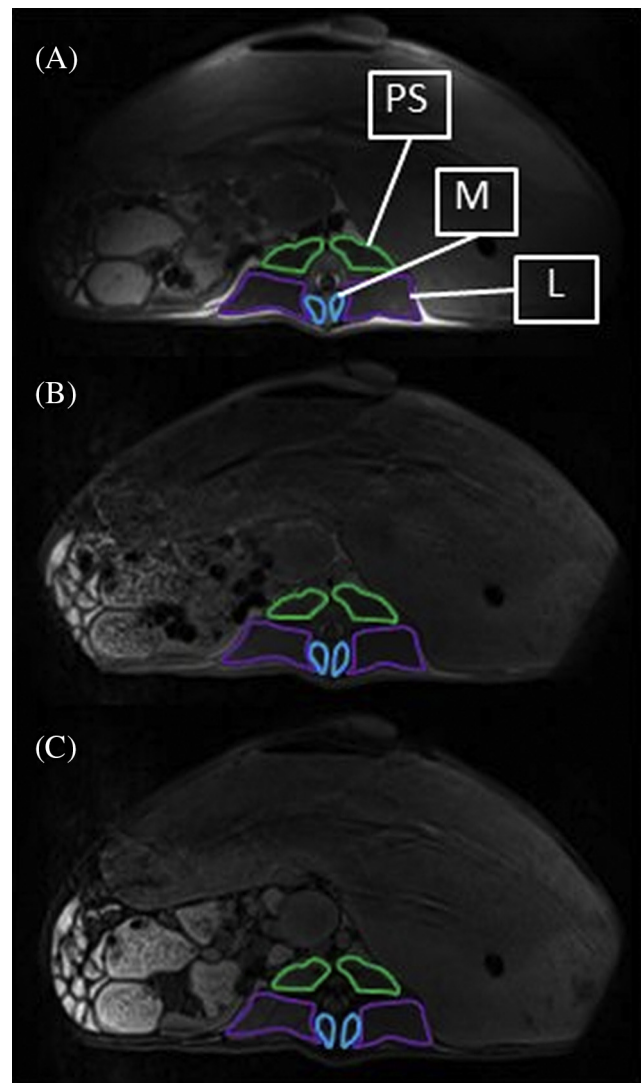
Region of interest of psoas major and minor (PS), multifidus (M), and longissimus (L) on both sides of L4 in (A) T1-weighted, (B) Dixon in-phase, and (C) Dixon oppose-phase axial images.
